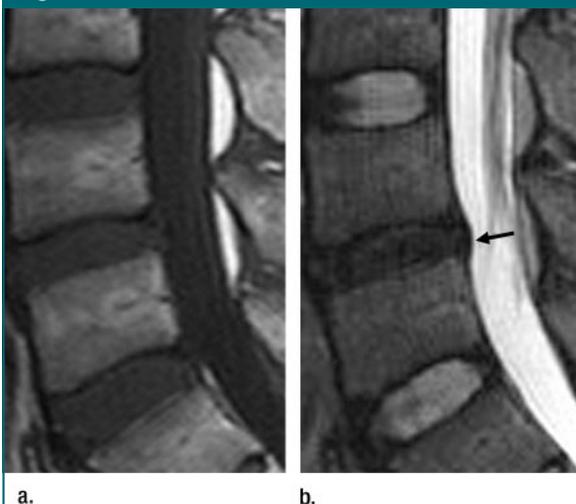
Degenerated L4-5 disk. Sagittal midline (a) T1-weighted SE (450/15) and (b) T2-weighted fast SE (4000/120) images show mild reduction in L4-5 disk space and loss of signal intensity on b. There is mild convex posterior bulging of the intervertebral disk at this level (arrow). Note normal signal intensity and morphology of L3-4 and L5-S1 disks.
